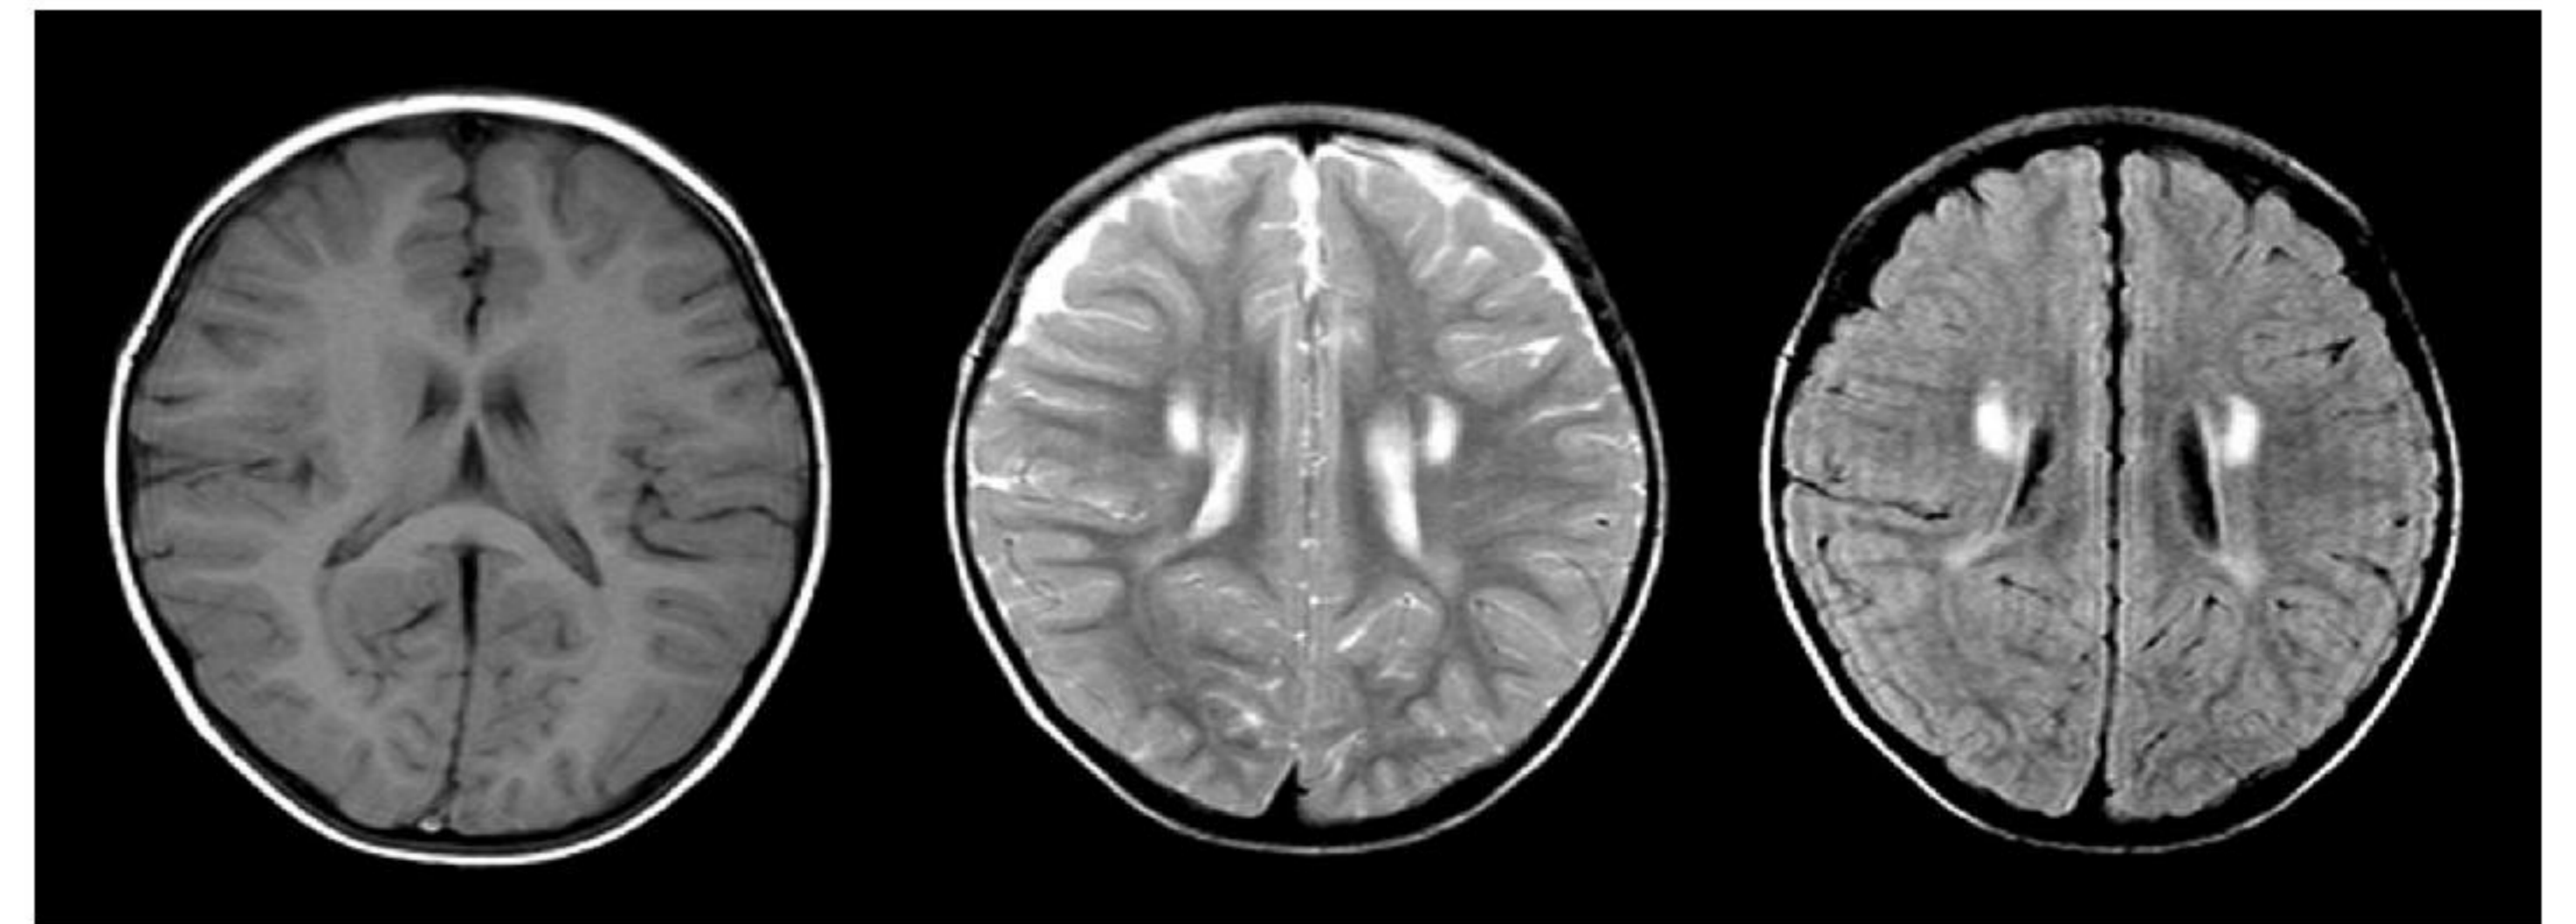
Magnetic resonance imaging (MRI) of the brain at the age of 21 months. MRI demonstrated symmetric high signal intensity of periventricular white matter on T2-weighted and FLAIR images, suggesting hypoxic anoxic encephalopathy or metabolic encephalopathy. The myelination and migration of underlying brain was normal. No other structural abnormalities including ventricle dilatation or encephalomalatic change were detected.
